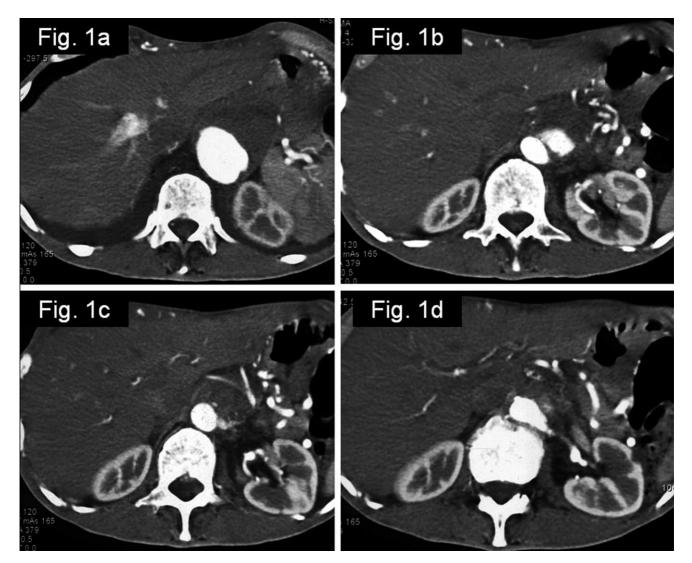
Pre-operative CT scan of the thoraco abdominal aorta showing the short sovrarenal aortic neck (1 cm) and the 'cul de sac' (b) of the lower thoracic aorta aneurysm over the renal arteries.
